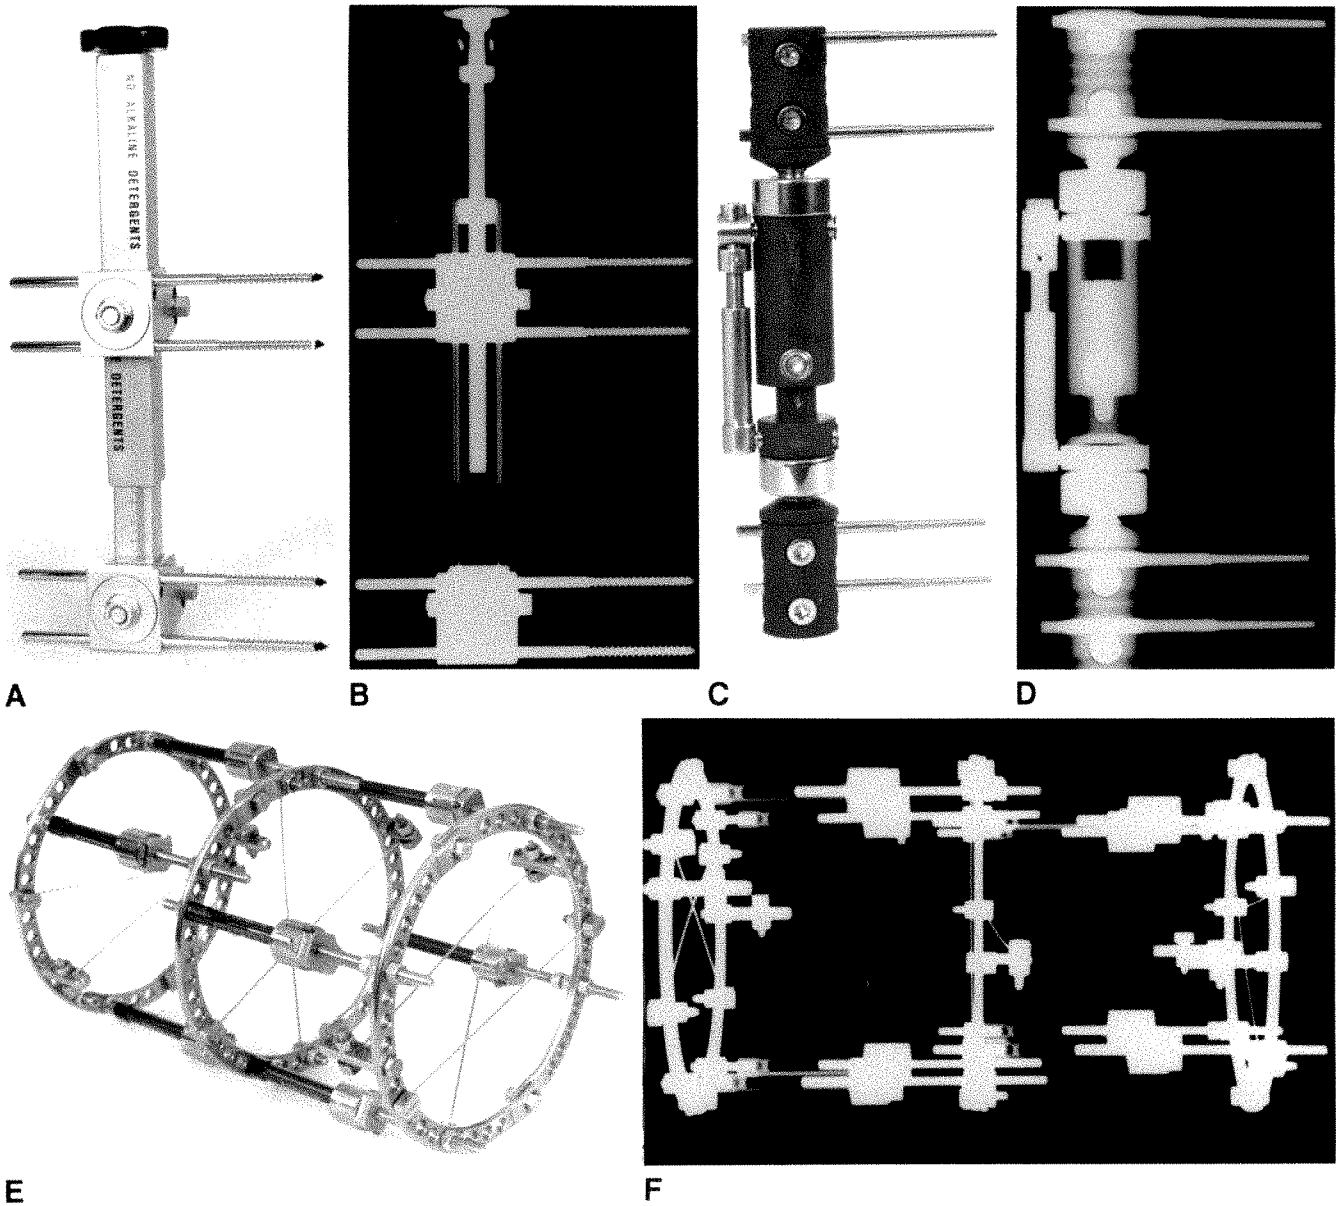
A–F, Photographs and radiographs of Wagner (A, B) and Orthofix (C, D) unilateral fixators and circular Ilizarov fixator with wires (E, F).
